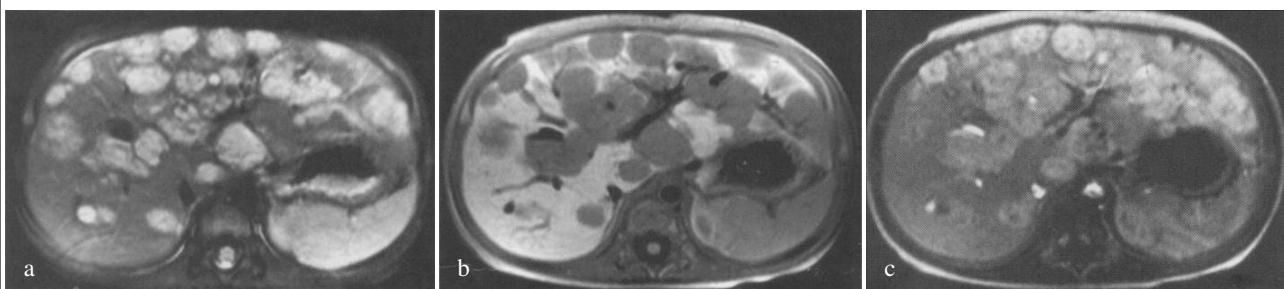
Infantile hemangiopericytoma - 18 month old boy: a) T2-weighted fat-suppressed shows multiple nodular lesions, small size, under 1cm, appear in high signal intensity; b) the lesion in T1- weighted before contrast; c) T1- weighted fat-suppressed on the interstitial-phase, after homogeneously gadolinium enhanced.
